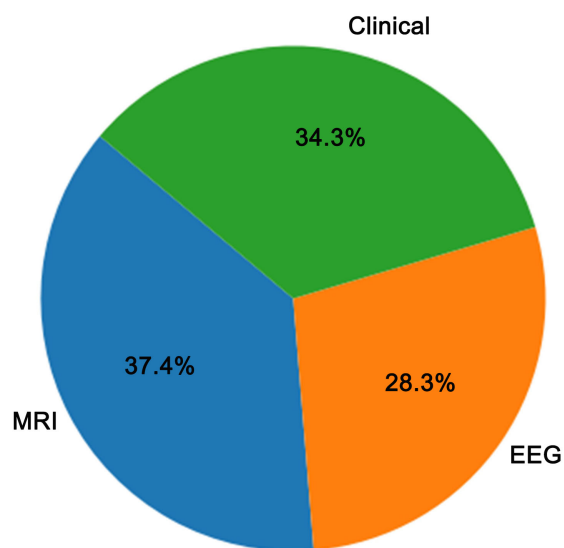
Relative contributions of MRI, EEG, and clinical features to fused AUC.
